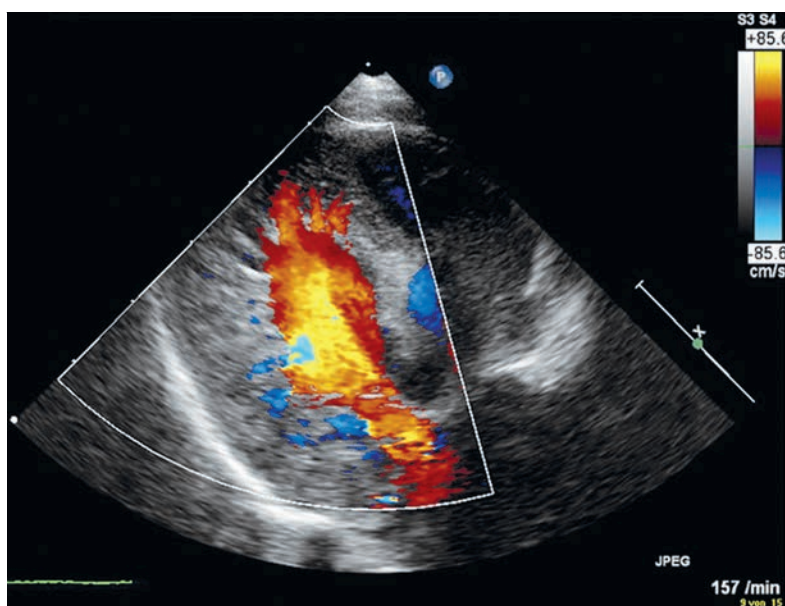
Noncompaction cardiomyopathy. Color Doppler TTE of an infant with isolated noncompaction cardiomyopathy of the left ventricle. The deep, blood-filled recesses are clearly visible, especially at the apex.
